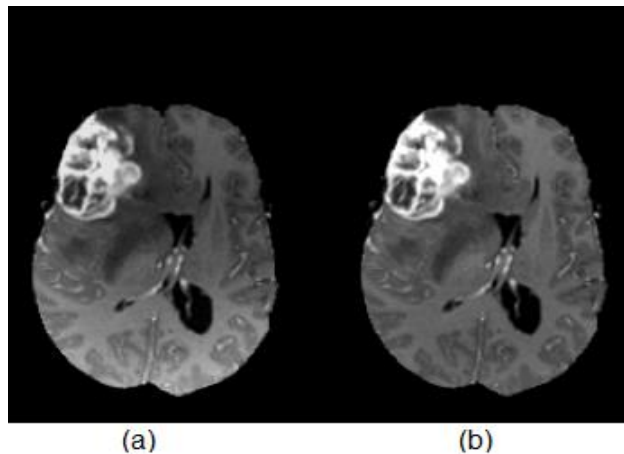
2 (a) MRI scan before (b) MRI scan after bias filed correction.
